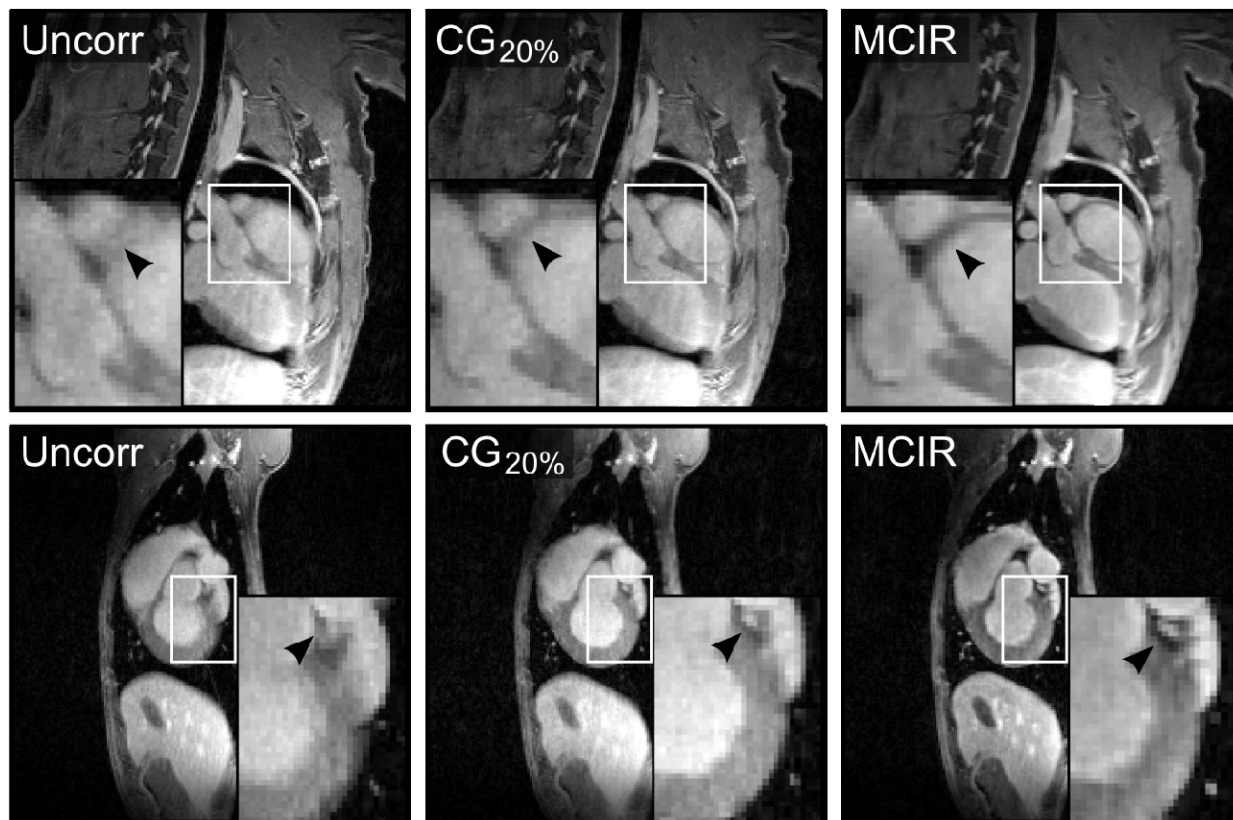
Results of MR MCIR. Comparison of uncorrected (Uncorr), cardiac gated (CG_{20%}) and motion corrected (MCIR) MR images in two different subjects. MCIR leads to a better depiction of myocardial wall and coronary arteries (black arrows).
